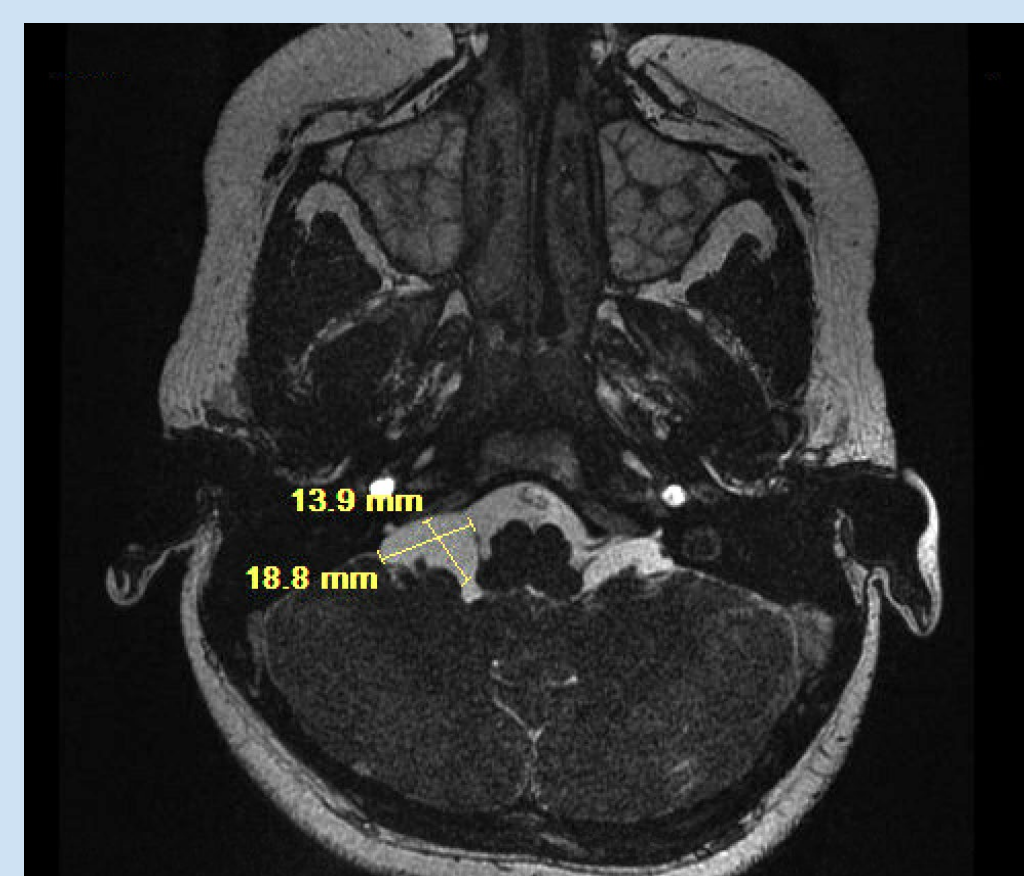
Case 5, right cerebellar medullary arachnoid cyst (MRI).
